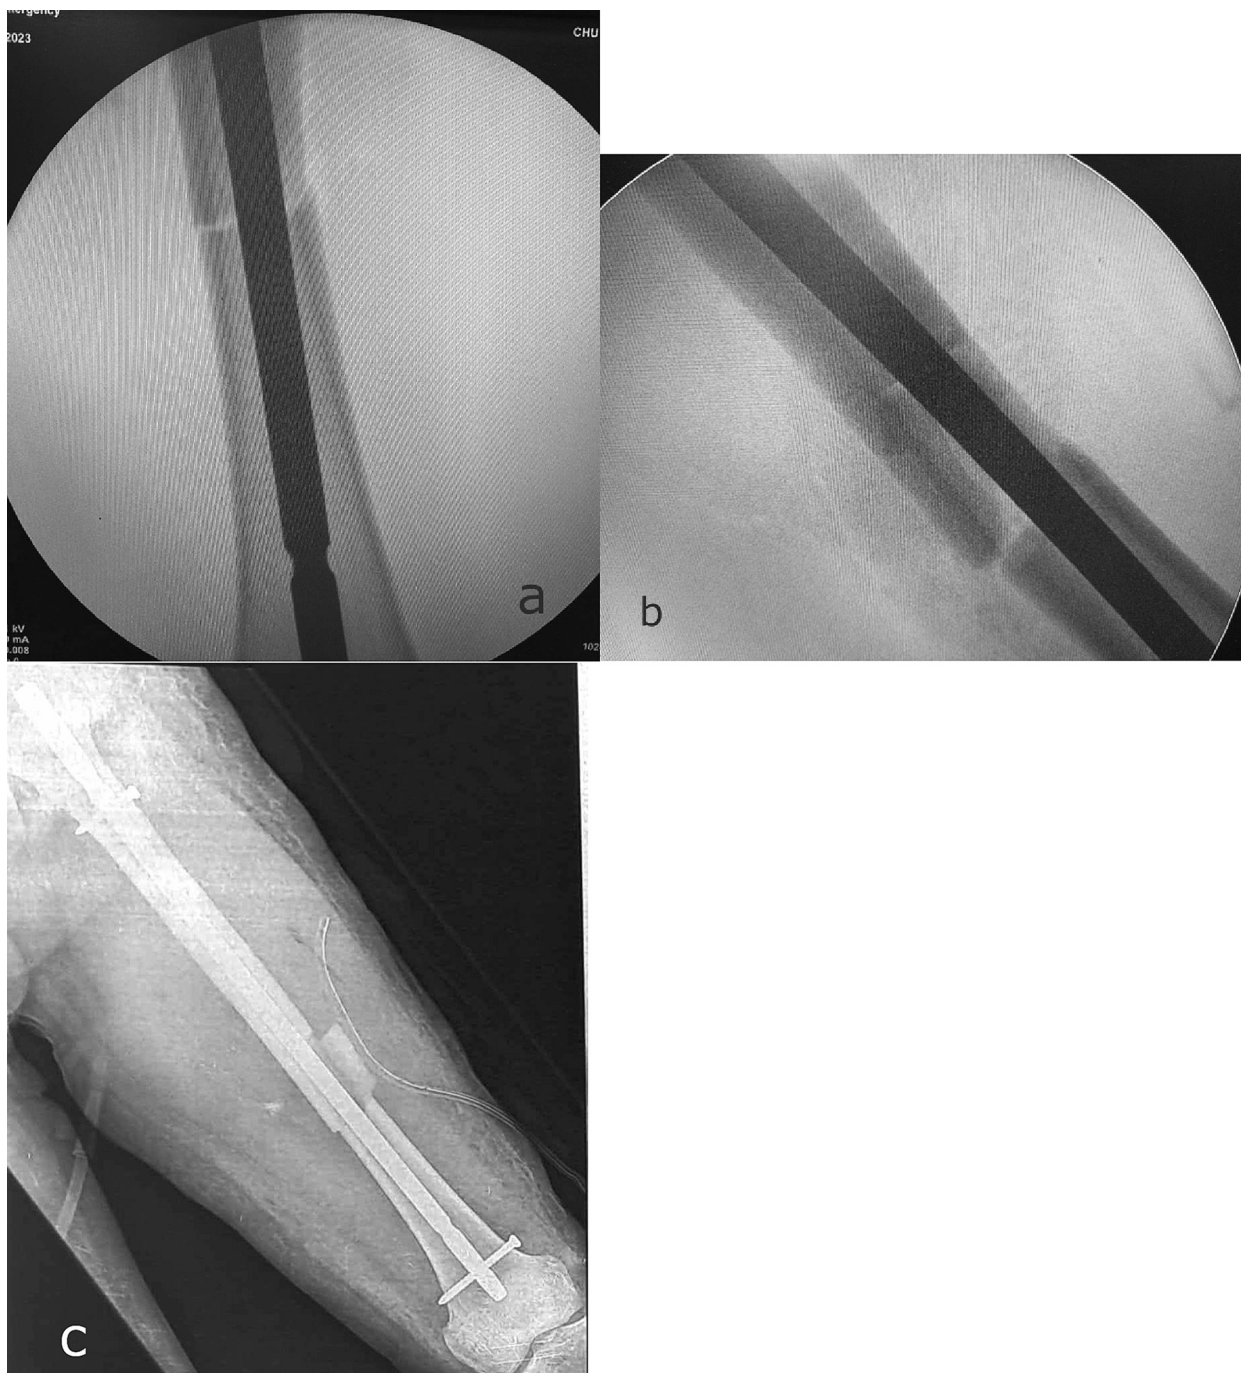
Post-operative fluoroscopy (a and b) and control X-ray (c) showing the good reduction of the fracture and the repositioning of the cortical bone window.
